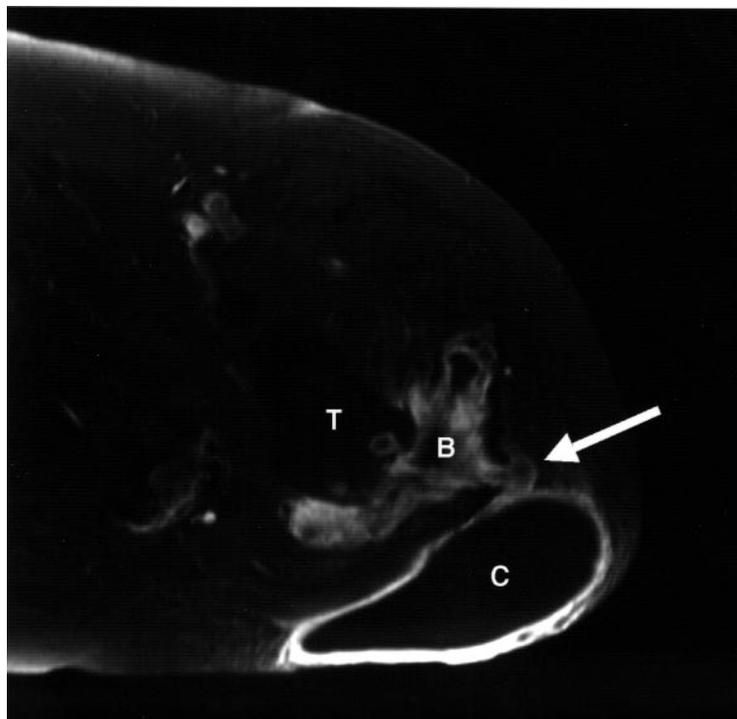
Gd enhanced MRI. The walls of the subcutaneous cyst (C) and the trochanteric bursa (B) are enhanced. There is a communication between them (arrow).
